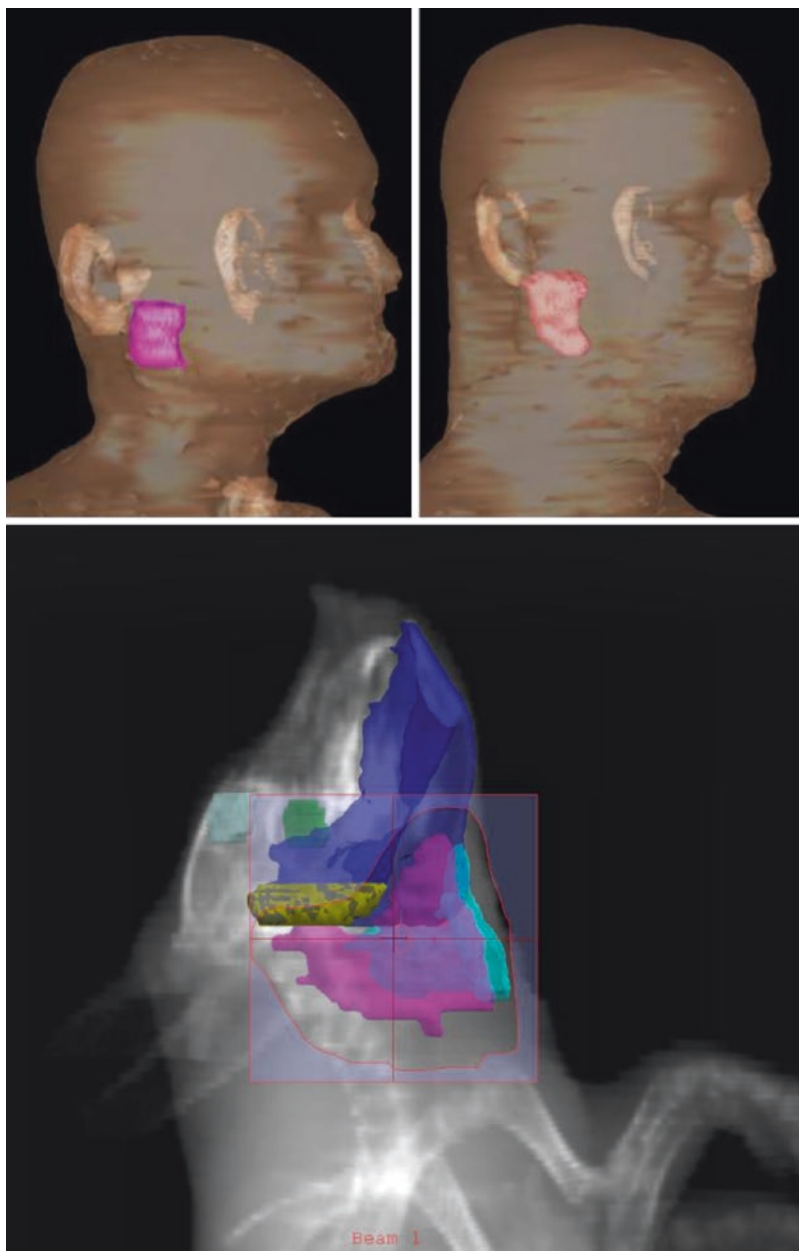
Comparison of parotid gland position and relative size and humans versus miniswine. *Upper* shows digital radiography reconstruction (DRR) of parotid glands from two de-identified patients from the Allegheny Cancer Center (Pittsburgh, PA). The *lower*
